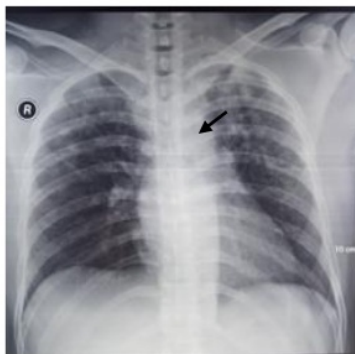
The AP chest X-ray shown that lung inflammation caused by specific process (TB process) and paravertebral soft tissue mass at the left side T5-T10 levels.
